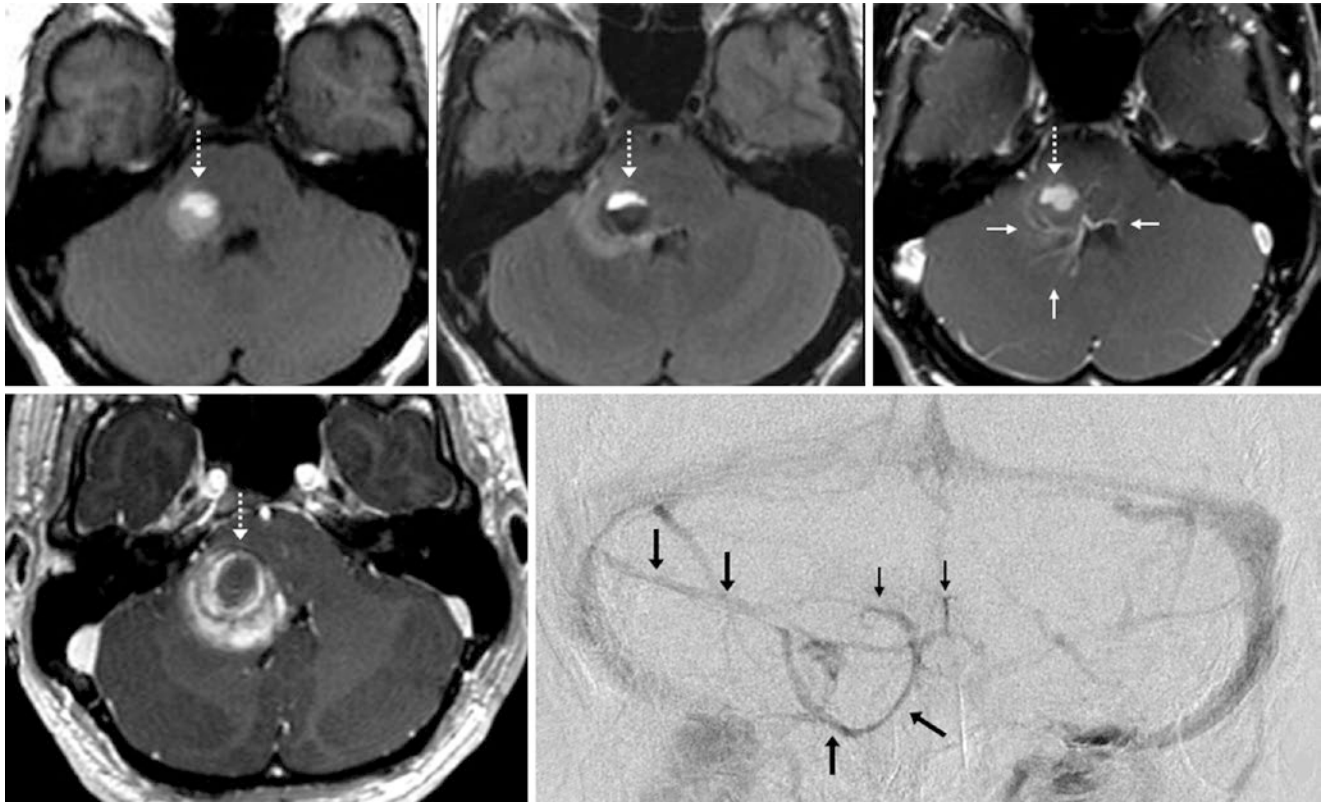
Comparison case of a cavernoma with a DVA. A 30 year old with an acute headache: On a 1.5T MRI, there was hemorrhage within the right middle cerebellar peduncle (*dotted arrows*) on SE T1WI (*top left*), FLAIR (*top middle*), and on postcontrast SE T1WI (*top right*), with enhancing caput vessels from an underlying DVA (*thin*
